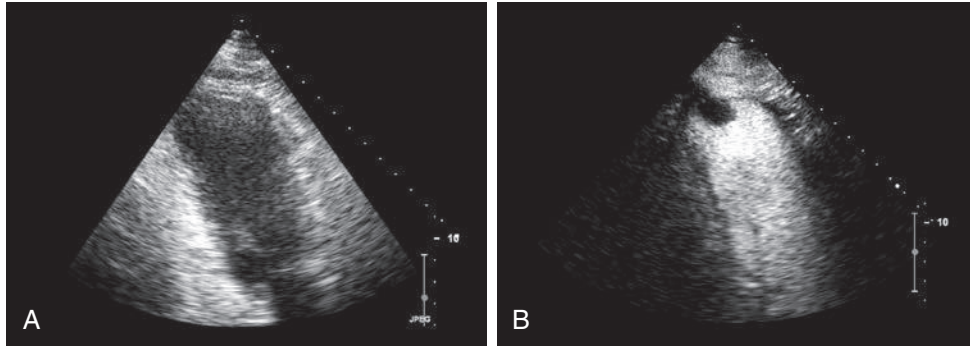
e8 Apical views of (A) noncontrast and (B) contrast transthoracic echocardiography. Note the anteroapical regional wall motion abnormalities and the demonstration of a filling defect at the left ventricular apex by contrast echocardiography (right), which is consistent with a left ventricular apical thrombus measuring 1.5 × 2.3 cm. (From Tsang MG, et al: *Echocardiography in acute myocardial infarction*. In Lang RM, et al, editors: ASE's comprehensive echocardiography, 3rd edition. Philadelphia, Saunders, 2016.)
